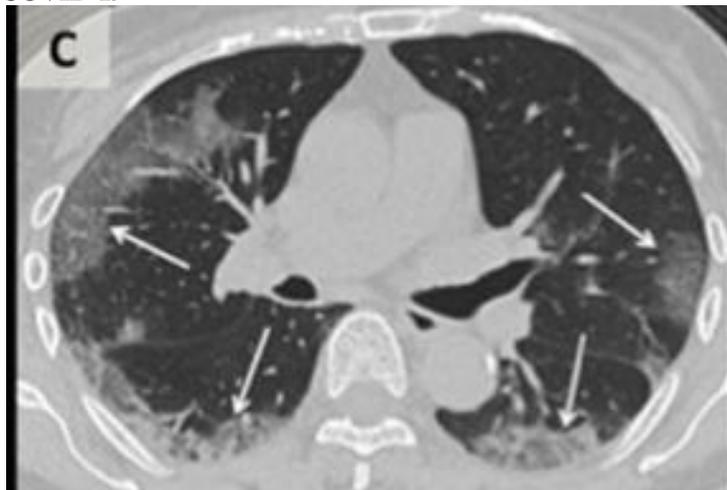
(a,b):- Axial sections of CT chest in lung window show multifocal confluent ground-glass opacities and mixed ground-glass with patchy consolidation in both lungs. Reference 6.
